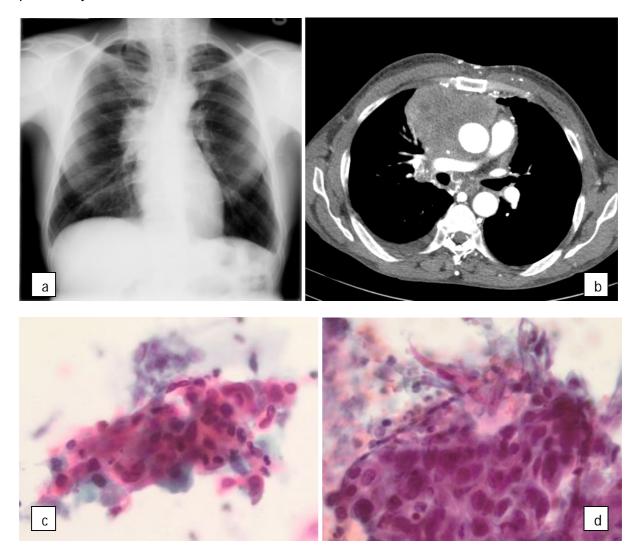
Large mass involving the right upper lobe and invading the mediastinal structures on chest X-ray (a) and CT (b). Sputum - malignant. Clusters of cells present with hyperchromatic nuclei and keratinised cytoplasm (c). TTNA - Squamous cell carcinoma with hyperchromatic nuclei (d).
